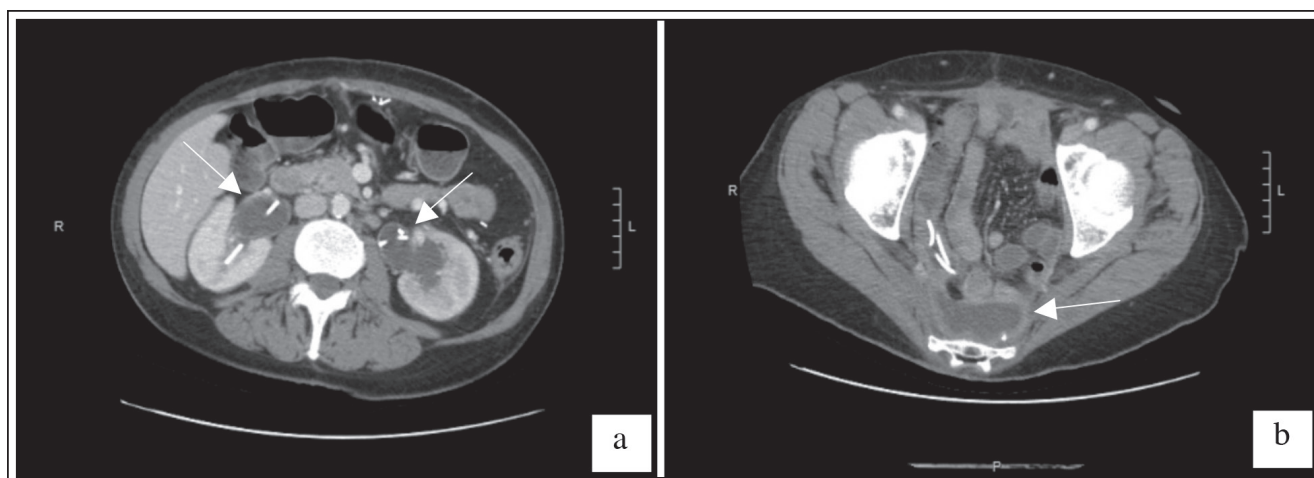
CT urogram demonstrating (a) bilateral hydronephrosis and hydroureter and (b) a 6.2 x 2.3 x 5.2 cm pre-sacral fluid collection.
